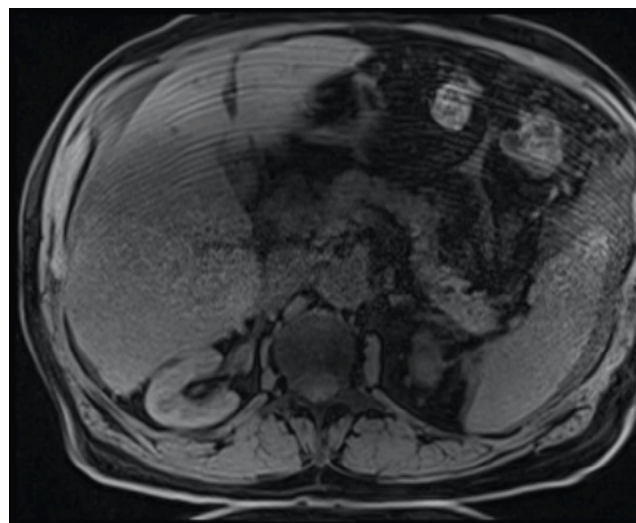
Magnetic resonance imaging (MRI) – Arterial phase: Potential hyperenhancement of hepatocellular carcinoma (HCC) lesions can be observed.
